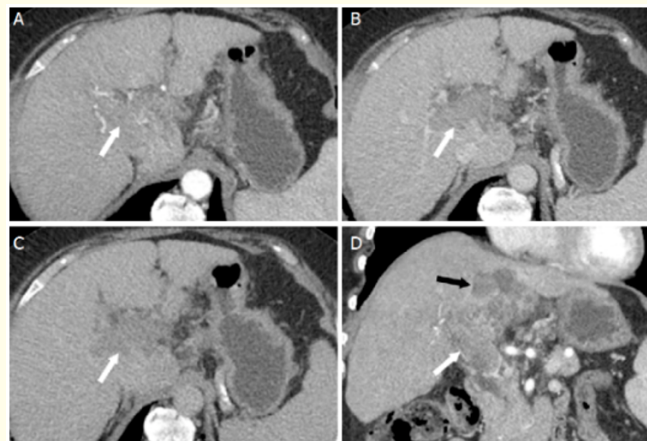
Shows LR-TIV. Axial CT images from the hepatic arterial (A), portal venous (B), and delayed (C) phases after intravenous contrast administration, hepatic arterial phase (D) [3].
